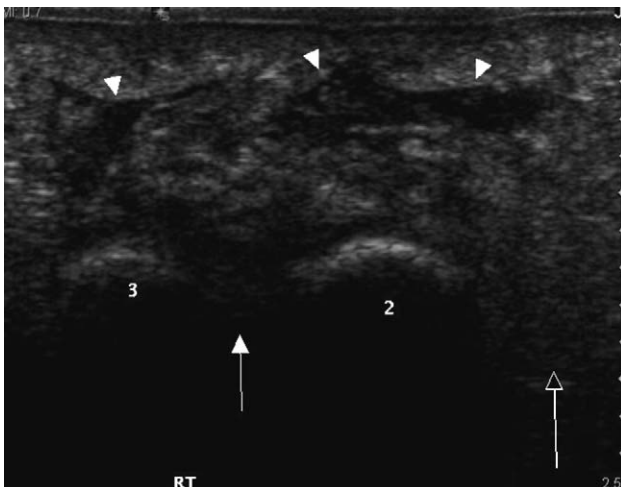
Transverse sonographic image of the plantar surface at the level of the metatarsal heads. The normally echoic fat pad has focal areas of fluid, 'black zones' (arrowheads), superficial to the second and third metatarsal heads representing adventitial bursitis. The normal intermetatarsal region is echoic (black arrow), whereas the abnormal intermetatarsal region is hypoechoic, representing a Morton's neuroma (white arrow).
